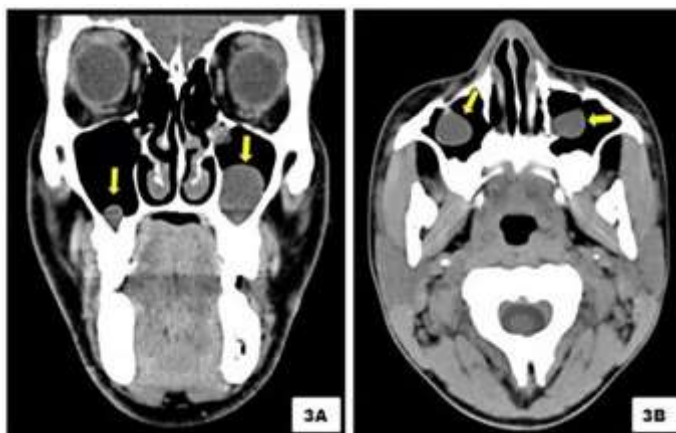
Computed Tomography scan - coronal view (Fig. 3A) and axial view (Fig. 3B) shows bilateral presentation of polyp in maxillary sinus (yellow arrow)
